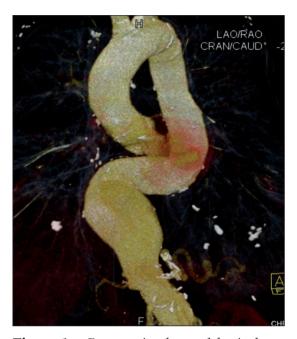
Pre-operative thoracoabdominal contrast enhanced computed tomography scan (computer 3D rendered) demonstrating oxbow shaped anuerysm extending from T8 to L2.
